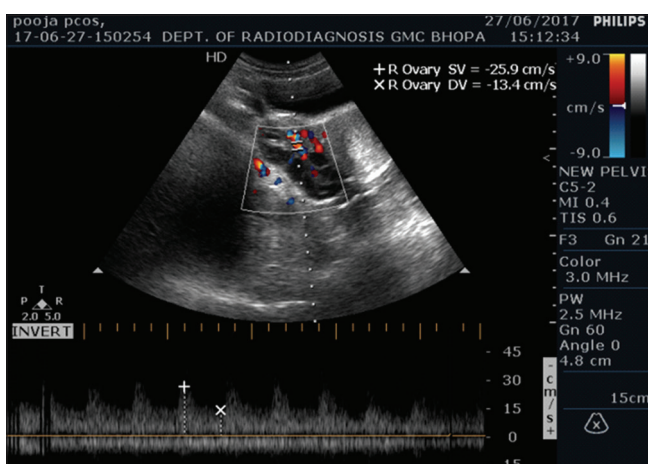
Color Doppler study showing increased ovarian vascularity and increased peak systolic velocity and end-diastolic velocity in a case of polycystic ovary syndrome
